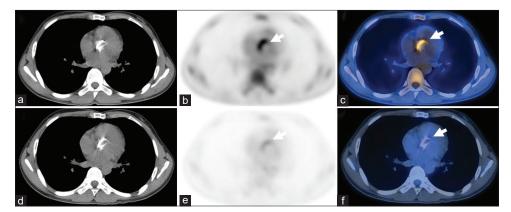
Top row: Baseline ¹⁸F-FDG PET/CT scan with axial Non-contrast CT (a) PET (b) and fused PET/CT (c) images showing increased FDG uptake in the region of prosthetic aortic valve (bold white arrows). Bottom row: Follow-up ¹⁸F-FDG PET/CT scan with axial noncontrast CT (d), PET (e) and fused PET/CT (f) images showing resolution of previously noted FDG uptake in prosthetic aortic valve region. ¹⁸F-FDG PET/CT: 18F-Fluorodeoxyglucose positron emission tomography/computed tomography
